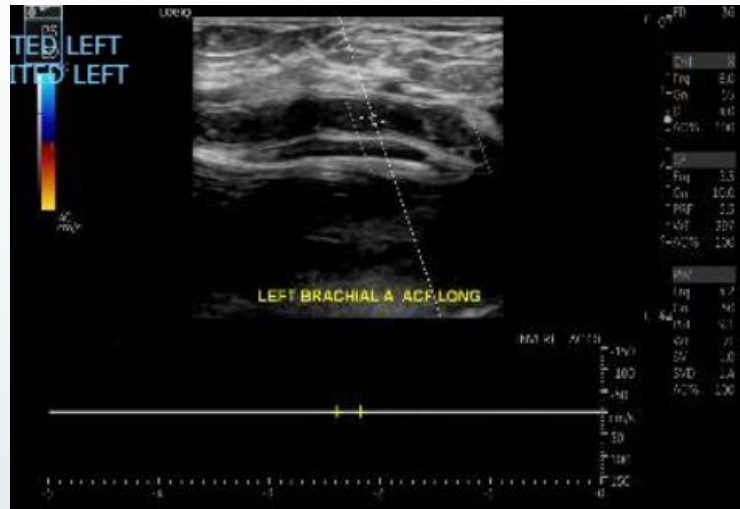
Ultrasound performed of the left brachial artery with no observable flow with use of Doppler
